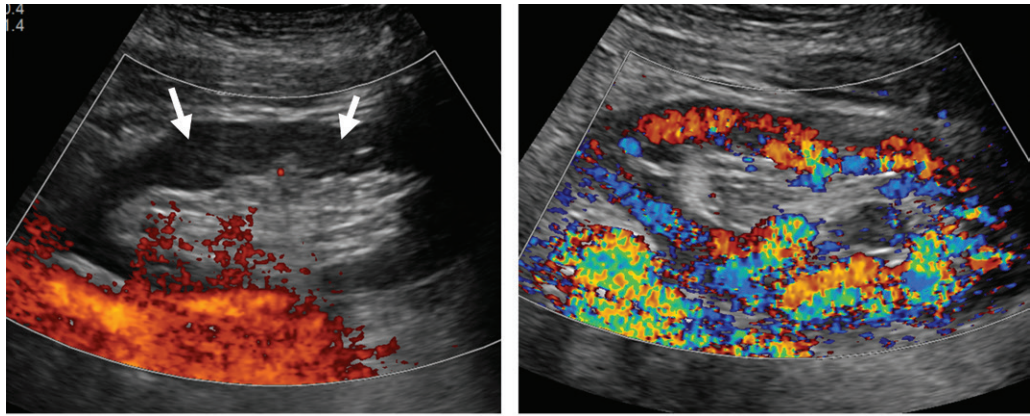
Renal allograft compartment syndrome in a 65-year-old woman after deceased donor renal transplant to the left iliac fossa. (a) Immediate postoperative power Doppler image of the left iliac fossa transplant kidney shows complete absence of cortical flow (arrows). Immediate reoperation was needed: The patient was returned to the operating room and the allograft was intraperitonealized, given concern for compartment syndrome due to fascial compression. (b) Follow-up color Doppler image of the kidney shows robust cortical flow.
